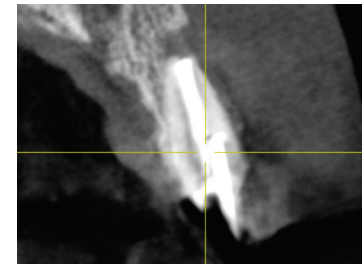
A 3-D X-ray rules out the possibility of redoing the endodontics and placing an immediate implant due to significant bone loss and infection at the end of the root. An implant can be placed later after extraction and bone grafting.
